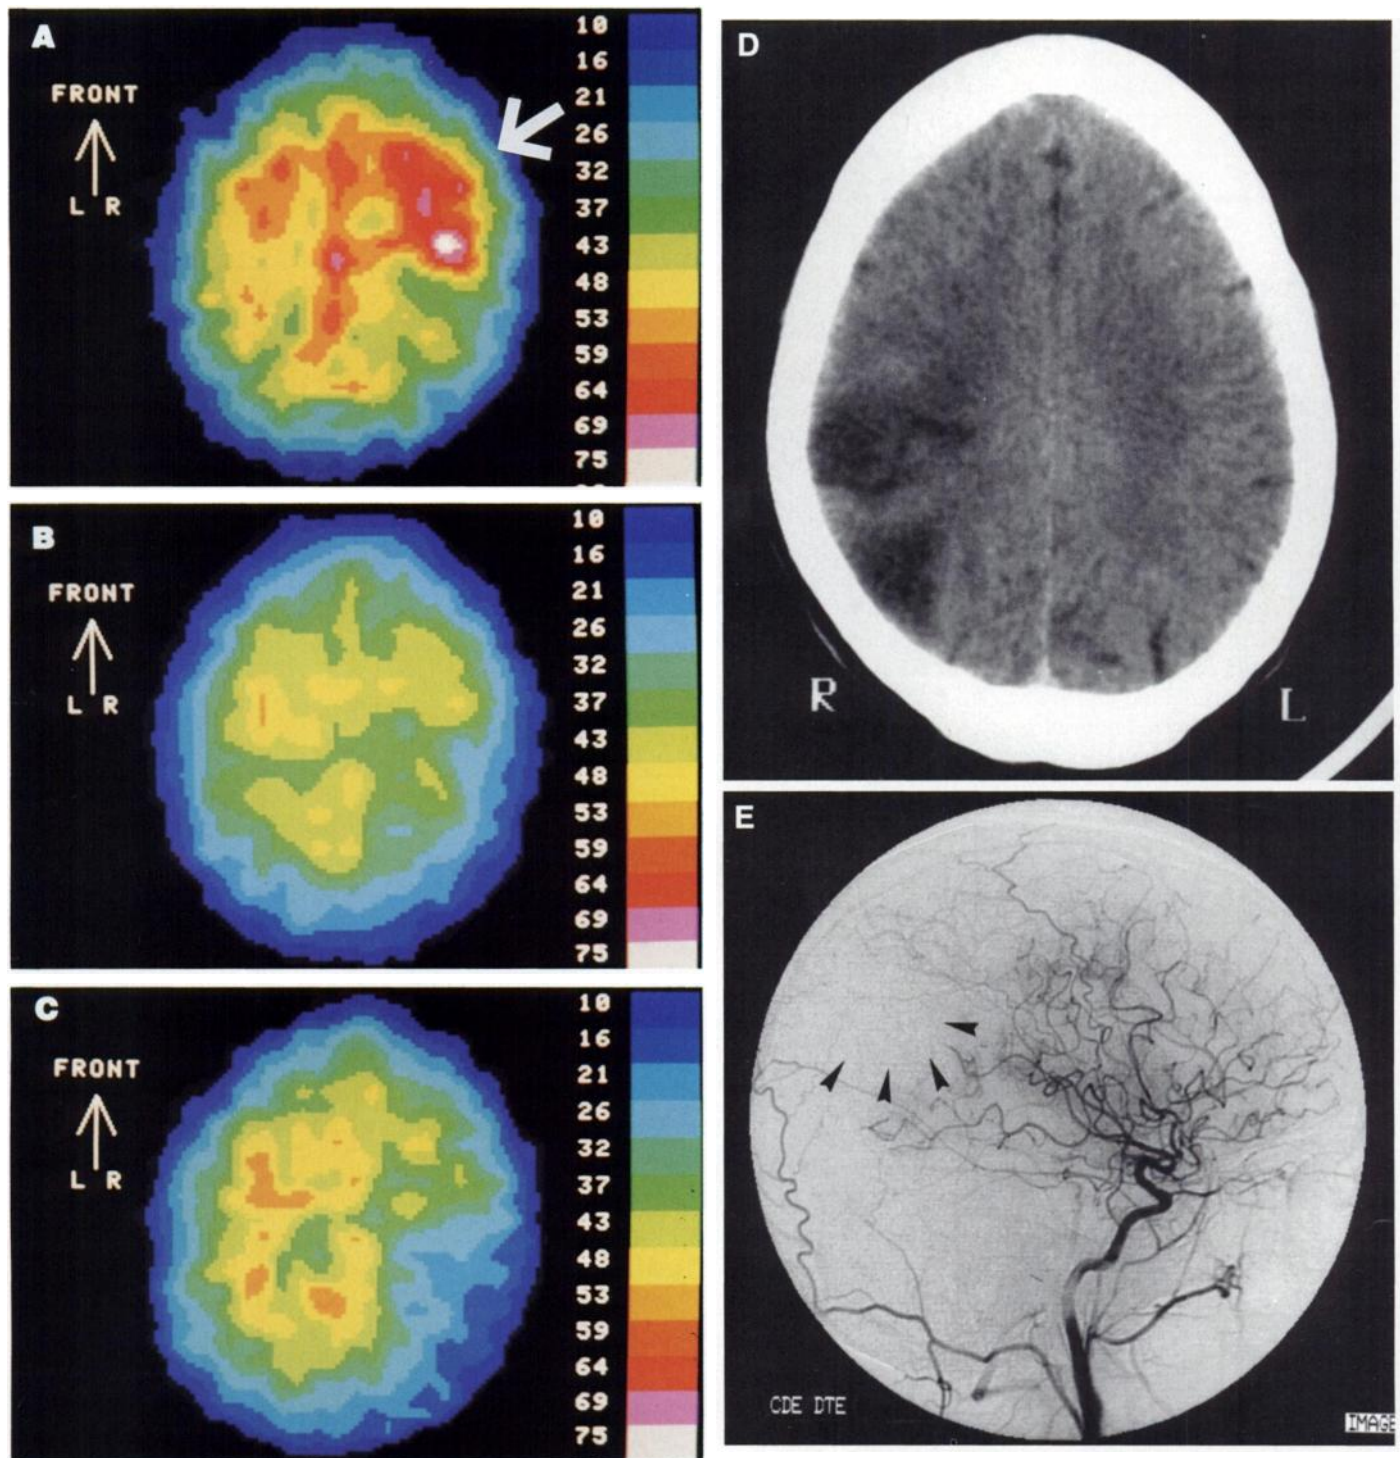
CPH assessed by quantitative ^{133}Xe -SPECT. Patient 14 (male, 42 yr) was hospitalized 3 days after the onset of brutal left hemiparesia due to a right internal carotid artery embolism. His initial clinical NIH1 score was 8. CT scan (day 3 after onset) shows right parietal hypodensity (D). (A) The first SPECT (Day 6) shows CPH located in the superior right frontorolandic region (arrow) neighboring a discreet right parietal hypoperfused area that matched the CT-scan abnormalities. The vasoreactivity of the CPH region to acetazolamide was slightly lower (+25%) than that of the contralateral region (+32%). (E) Angiography (Day 13) shows a persistent right temporoparietal defect (arrows) and functional right anterior and posterior communicating arteries as well as cortical anastomoses. (B) The second SPECT (Day 15) shows the arrest of CPH and a slight increase in the right parietal hypoperfusion. The 1-mo clinical score NIH2 was four. (C) The third SPECT (Day 82) shows that perfusion of the initial CPH region was almost normal, while considerable hypoperfusion remained on the right parietal region. All the CBF-SPECT have the same color scale.
